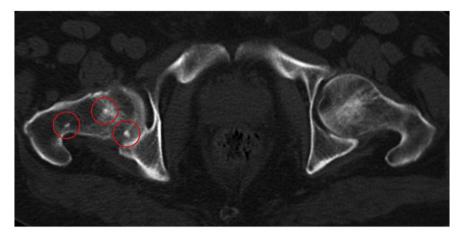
Detail of the right femur acquired from an ante-mortem CT-scan dating back to August 2009: the three dense bone islands circled.
